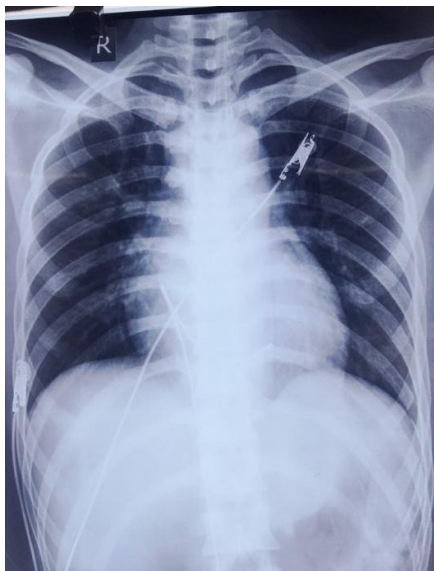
Chest X-ray showing temporary pacemaker and cardiomegaly
